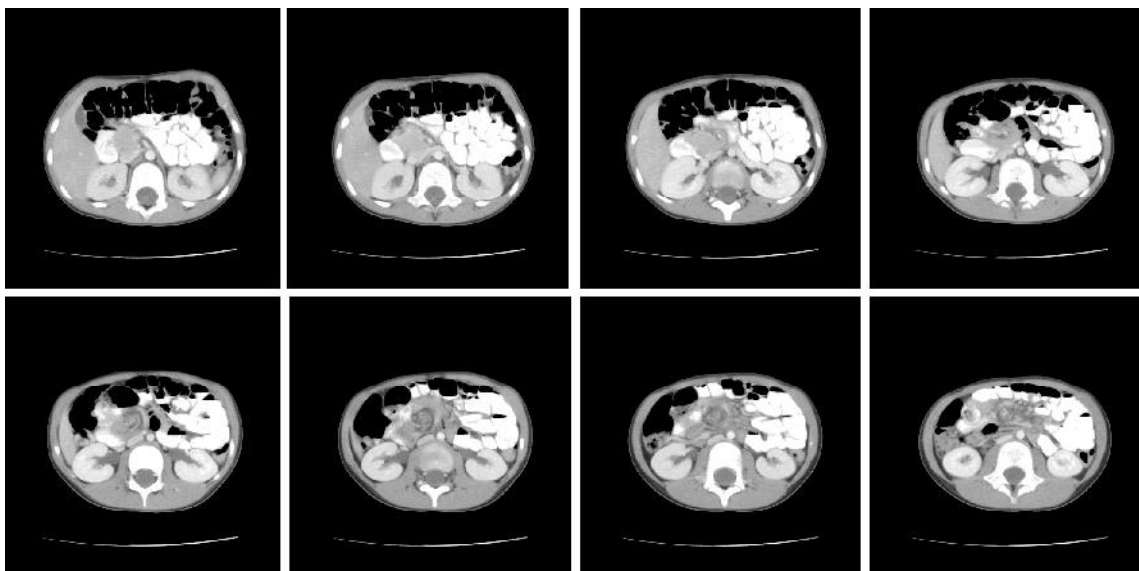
Contrast enhanced CT scan showing twisted appearance of volvulus of midgut (about 360° clockwise) around the mesenteric vessels
